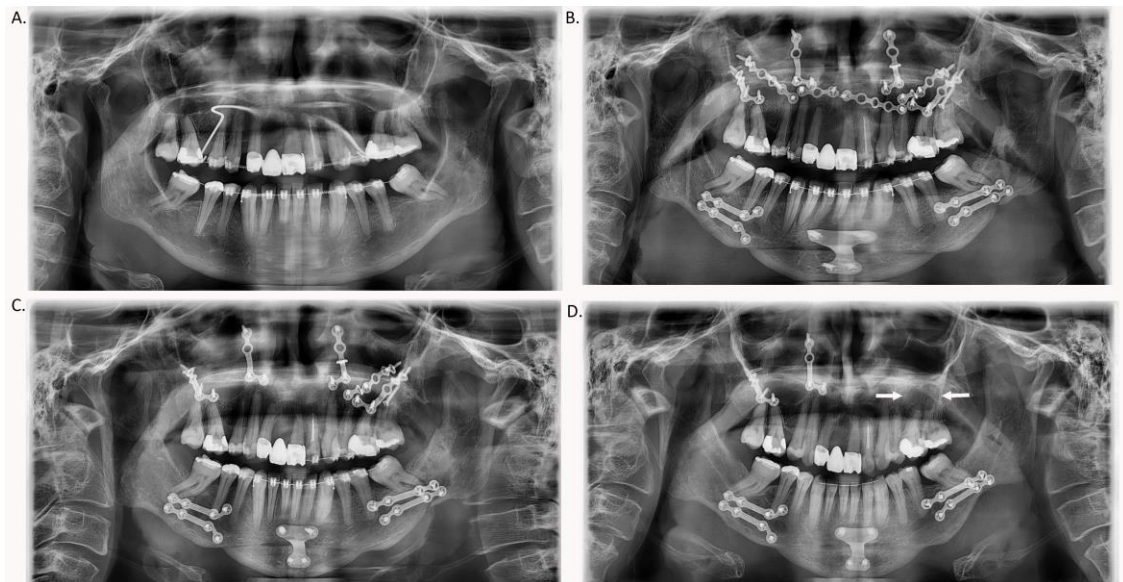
Panoramic radiographs. A. Preoperative. B. One-month postoperative. C. Four-month postoperative. D. One year postoperative showing surgical ciliary cyst.
